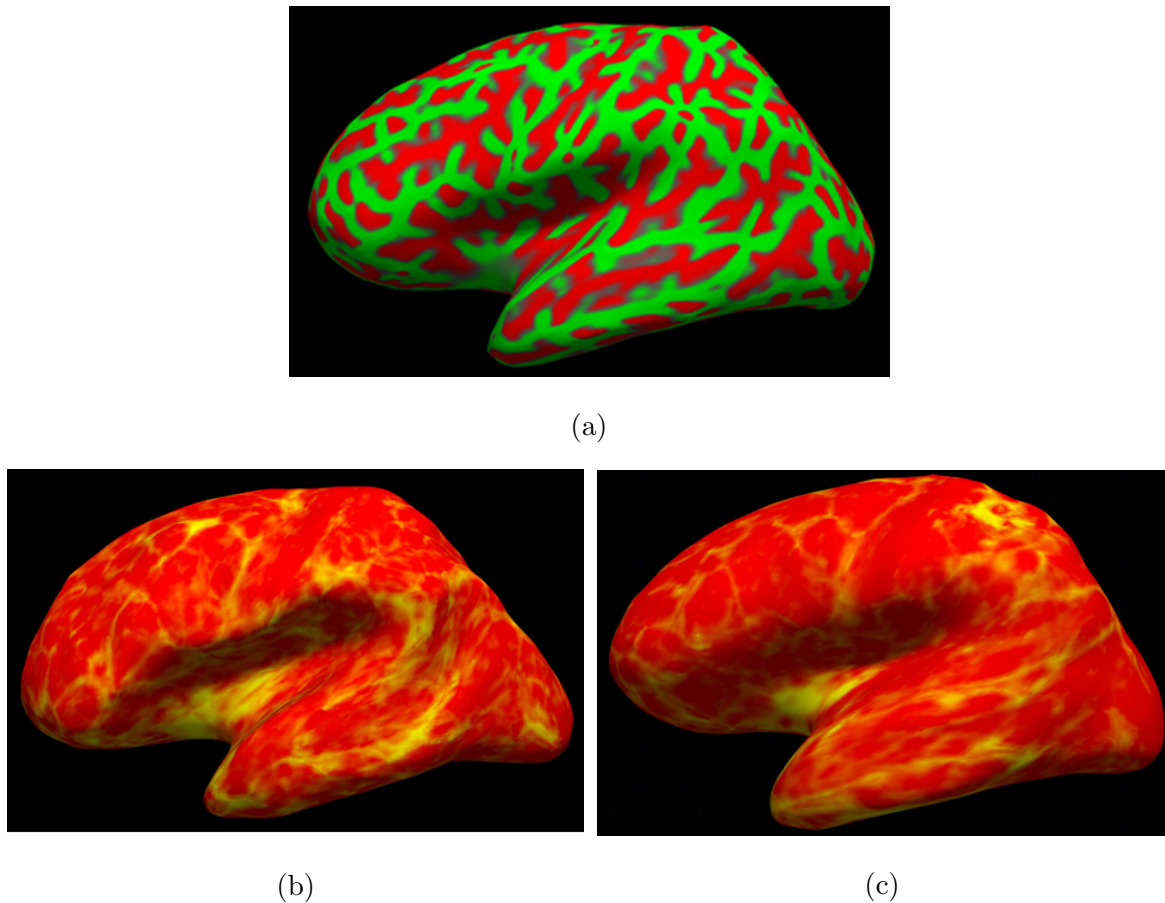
FreeSurfer inflated volumes: (a) Inflated MRI-Positive subject NL001 (red regions are sulci and green regions are gyri), (b) Cortical thickness values backprojected onto inflated volume of control NL030, and (c) Cortical thickness values backprojected onto inflated volume of MRI-Positive Case NL039. Surfaces can be inflated or flattened to aid in visualizing features, in this case cortical thickness. Comparing the control NL030 to the MRI-Positive subject NL039, we can note that both in healthy cases and FCD cases natural variations are present. There does appear to be a thicker region as indicated by the bright spot at the top of NL039. This does in fact correspond to the approximate location of the true lesion, however, further processing must be performed to improve detection.
